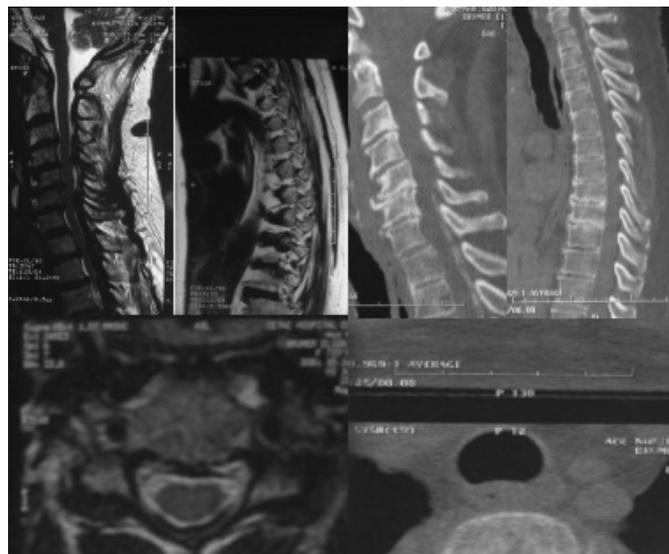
A. MRI with hypointense signal in the longitudinal posterior portion of the vertebral canal in cervicothoracic transition on sagittal T2 sequence. B. Hyperdensity of posterior portion of spinal canal resembling a bone, evidence of ossification of ligamentum flavum on cervicothoracic transition.
